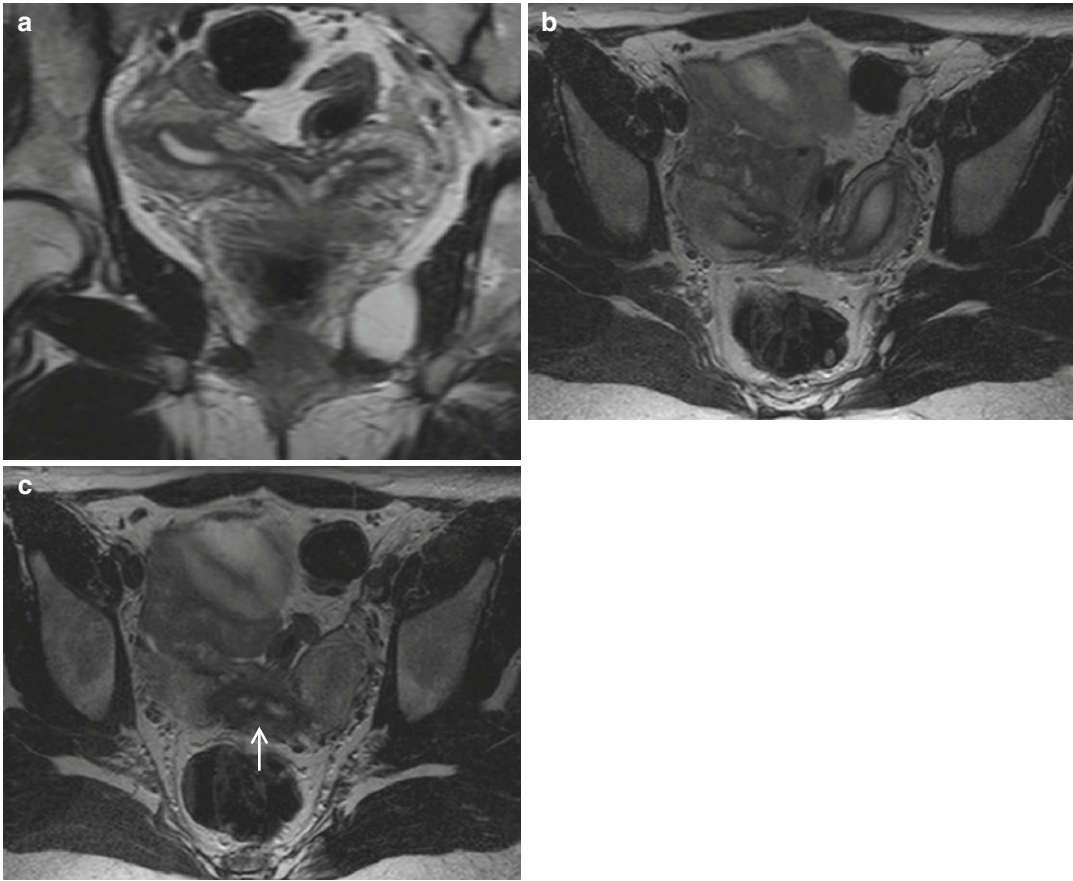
Complete bicornuate uterus (IVa). Fast spin-echo T2-weighted images on coronal (TR/TE 4070/94) (a) and axial plane (TR/TE 3070/108) (b, c) demonstrate
